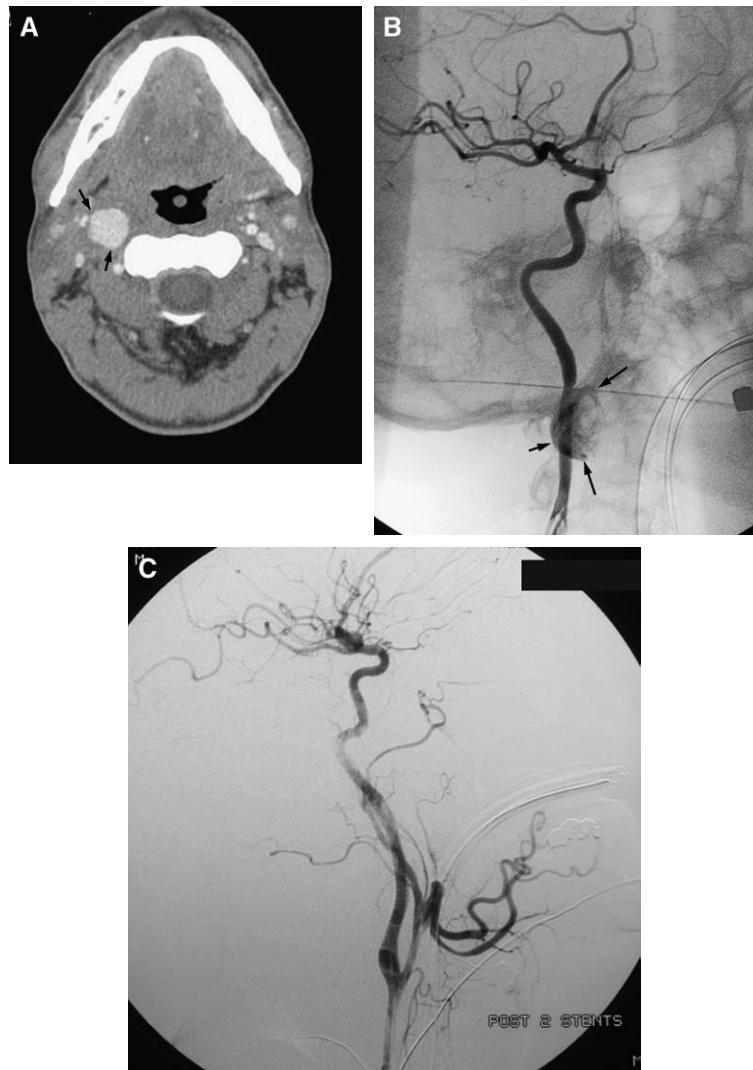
(A–C) Intimal dissection and pseudoaneurysm (arrows) 1 month after motor vehicle accident seen on CT for neck mass. Angiography was followed by overlapping stent placement with exclusion of the pseudoaneurysm.
